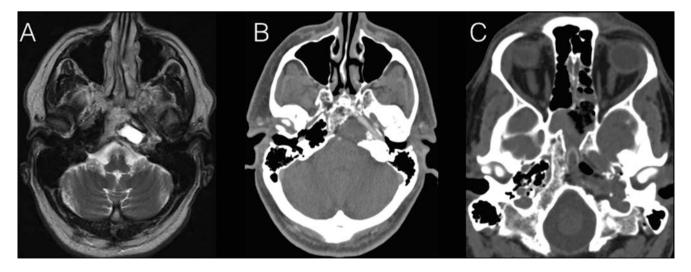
(a–c) Left PACG. (a) Axial T2 preoperative-weighted MRI showing a high signal lesion. (b) Axial CT angiogram showing an erosive cystic lesion. (c) Postoperative CT scan showing optimal decompression and correct positioning of the silastic stent
